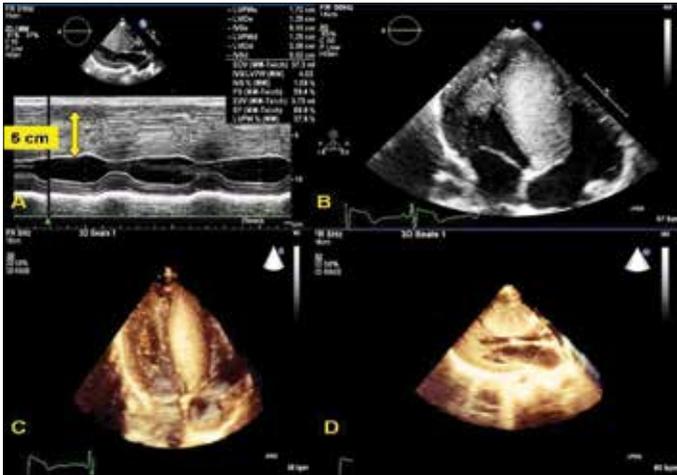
A. TTE image in parasternal long axis view shows interventricular septal thickness measurement is 5.1 cm B. TTE apical 4-chamber appearance of the giant interventricular septum C. 3D apical 4-chamber TTE shows giant interventricular septum D. 3D TTE parasternal long axis view of the giant interventricular septum
